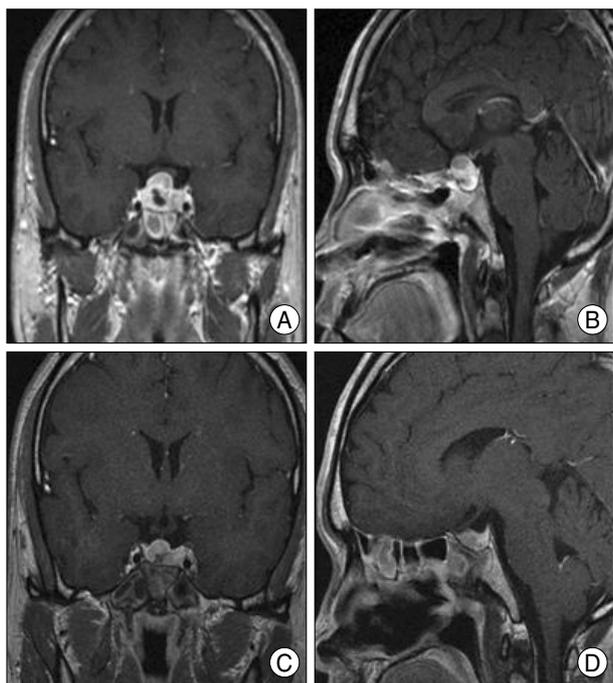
Magnetic resonance (MR) images obtained in case 6. Gadolinium enhanced coronal (A) and sagittal (B) MR images obtained at the CyberKnife radiosurgery (CKRS), Gadolinium enhanced coronal (C) and sagittal (D) MR images obtained 12 months after CKRS showing decreased size of pituitary adenoma at suprasella portion.
